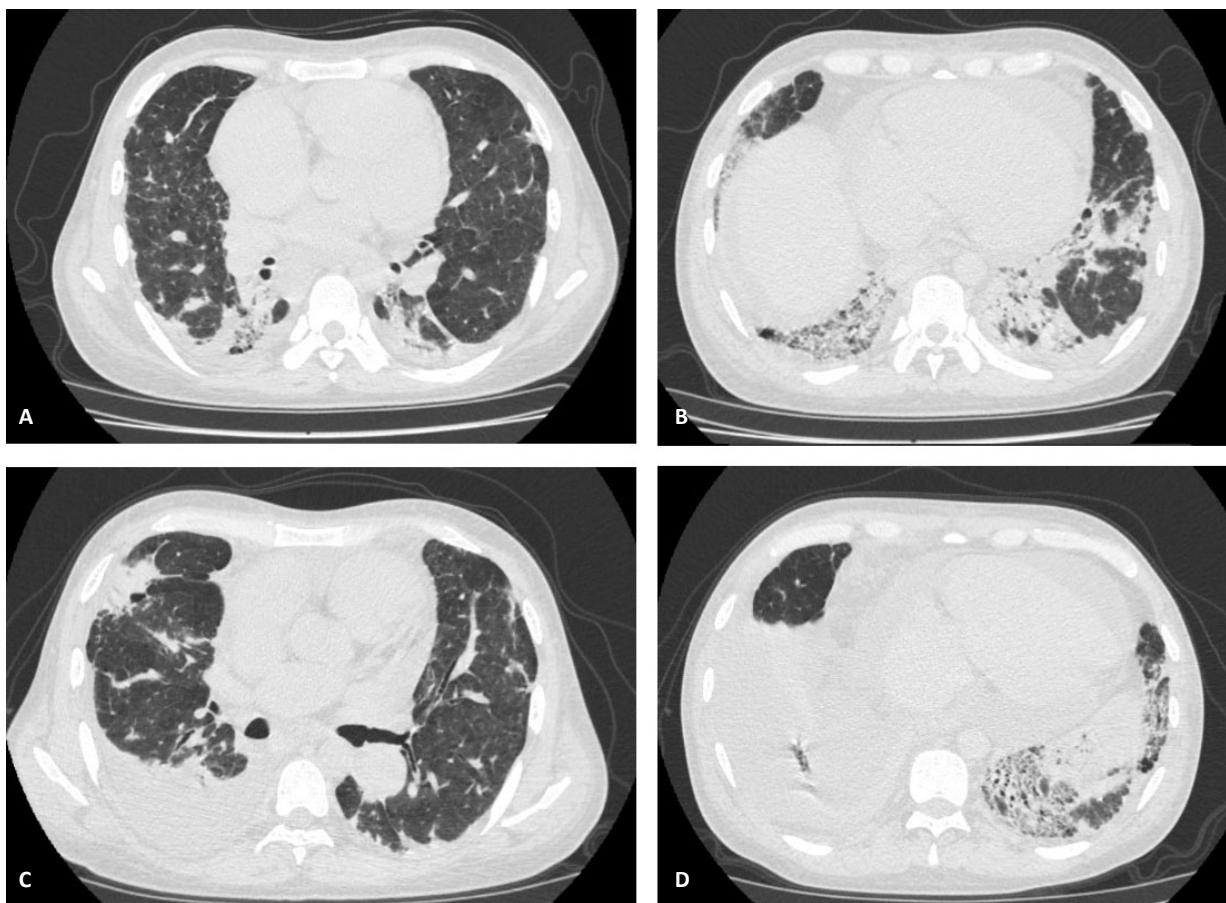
High-resolution chest CT (HRCT). A-B, January 2025 showing interstitial lung disease (ILD). C-D, June 2025 demonstrating interstitial progression and signs of pulmonary hypertension.
